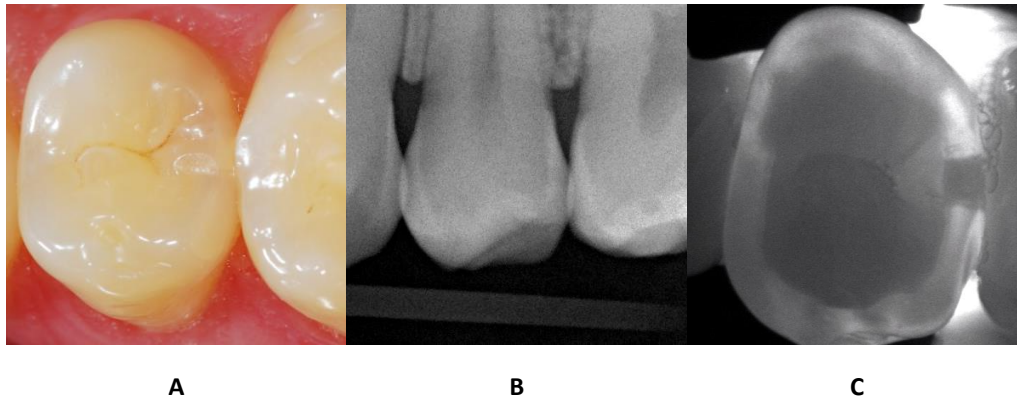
Tooth 15 distal: A) no visual signs of a proximal caries lesion; B) bitewing radiograph: radiological translucence resembling a proximal caries lesion in the outer half of the dentin (D3); C) NIRT image: a squared shading in the enamel with linear contact to the dentino-enamel junction (Code 4)
